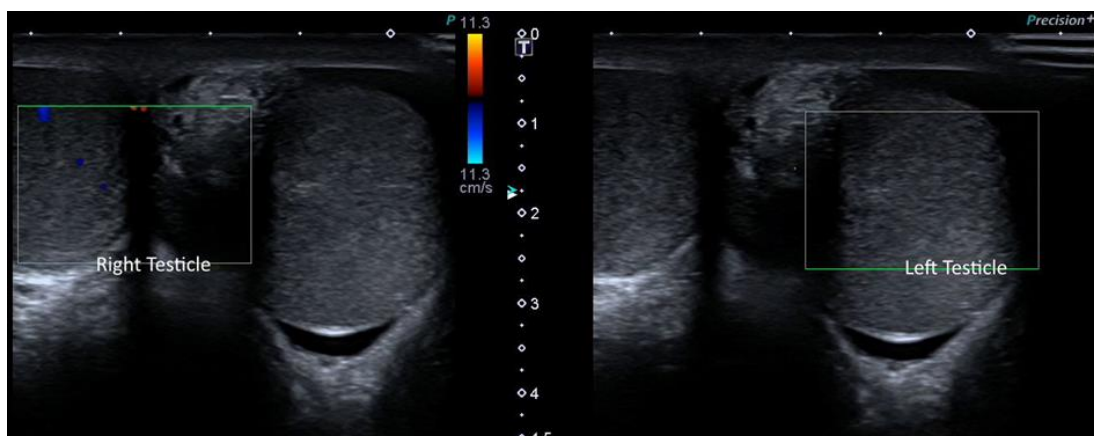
Bedside Scrotal Color Doppler Ultrasonography shows heterogeneous hypoechoic right testicular parenchyma with no blood supply and anechoic foci consistent with necrosis.
